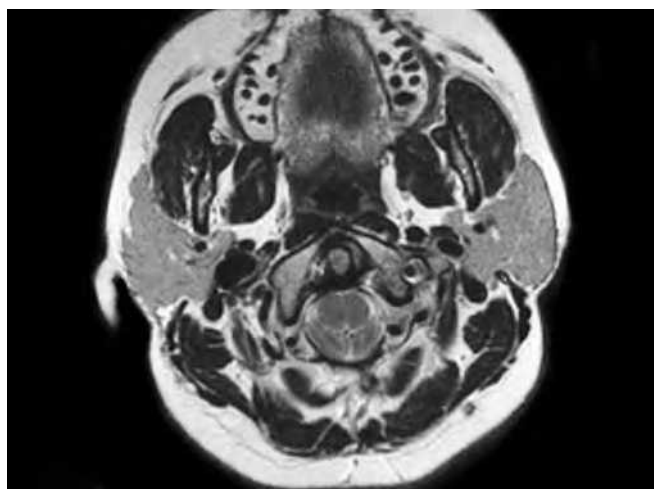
Axial T2 magnetic resonance imaging demonstrating crowding of the cerebellar tonsils at the level of the foramen magnum.
